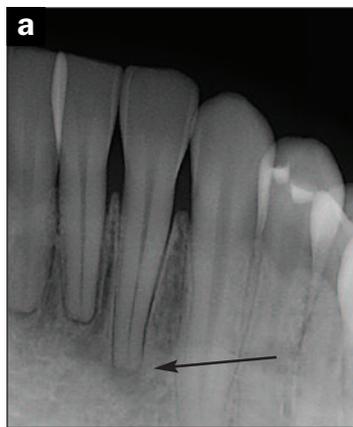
The digital periapical radiograph leaves the presence of a lesion of endodontic origin open to interpretation.
